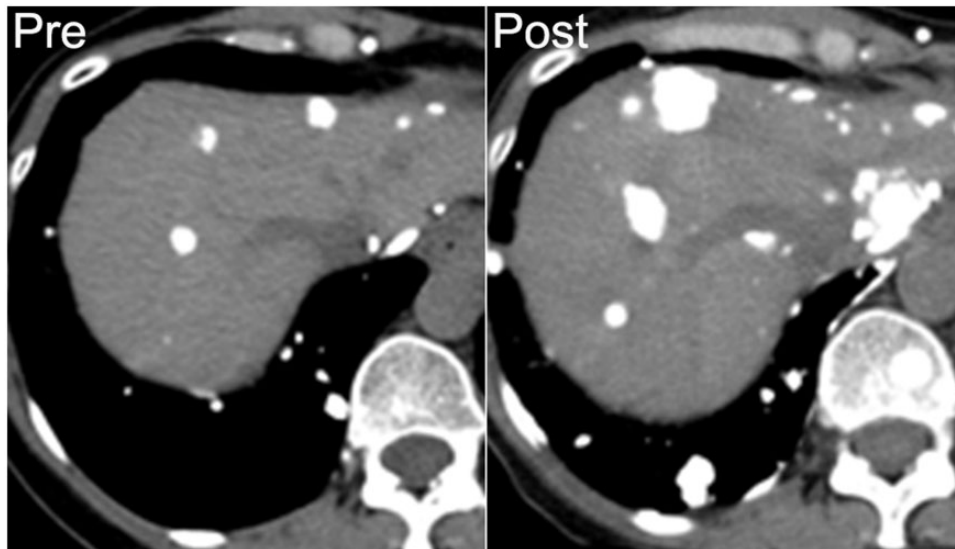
A 53-year-old woman with metastatic osteosarcoma arising from the sacrum. Mineralized lung and liver metastases are seen on axial noncontrast CT (left). She developed progressive disease after 8 months of chemotherapy, with increasing mineralization in both lung and liver metastases (right).
